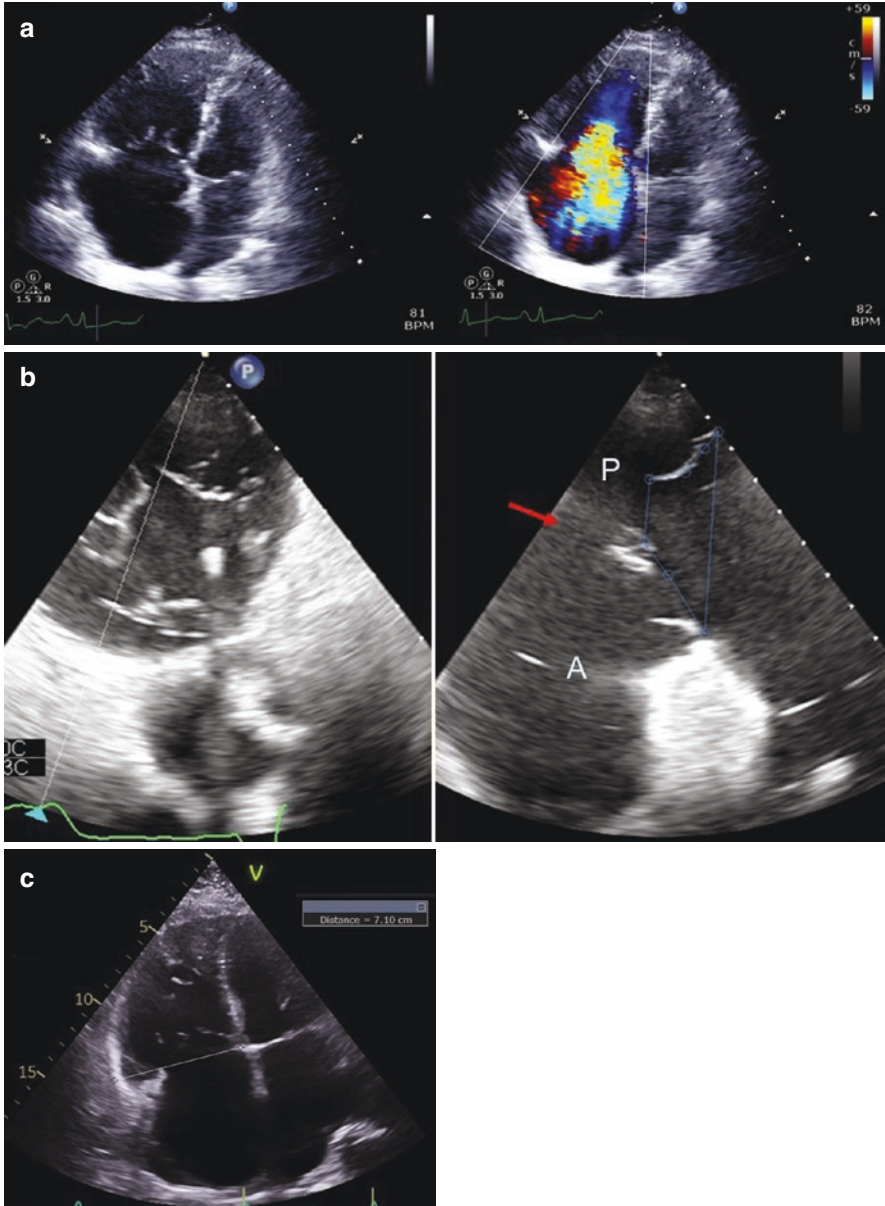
Secondary tricuspid regurgitation examples. (a) Tricuspid regurgitation due to pulmonary hypertension. Note the tethering of the tricuspid leaflets and lack of significant annular dilation leading to severe tricuspid regurgitation, with the origin of the color jet well below the annular plane (Video 5.3a). (b) Tricuspid regurgitation due to arrhythmogenic right ventricular cardiomyopathy. Left: Transgastric view of the tricuspid valve during early systole (Video 5.3b). Right: Orthogonal view across the posterior and anterior leaflets (see Video 5.3b). This patient has severe RV dysfunction and torrential tricuspid regurgitation, with a significant tenting area (blue outline) and coaptation gap (red arrow). (c) Idiopathic tricuspid regurgitation. Right ventricular focused apical four-chamber view in early systole showing severe RV enlargement, tricuspid annular dilation, and tricuspid leaflet mal-coaptation (Video 5.3c). This patient has idiopathic tricuspid regurgitation from atrial fibrillation
